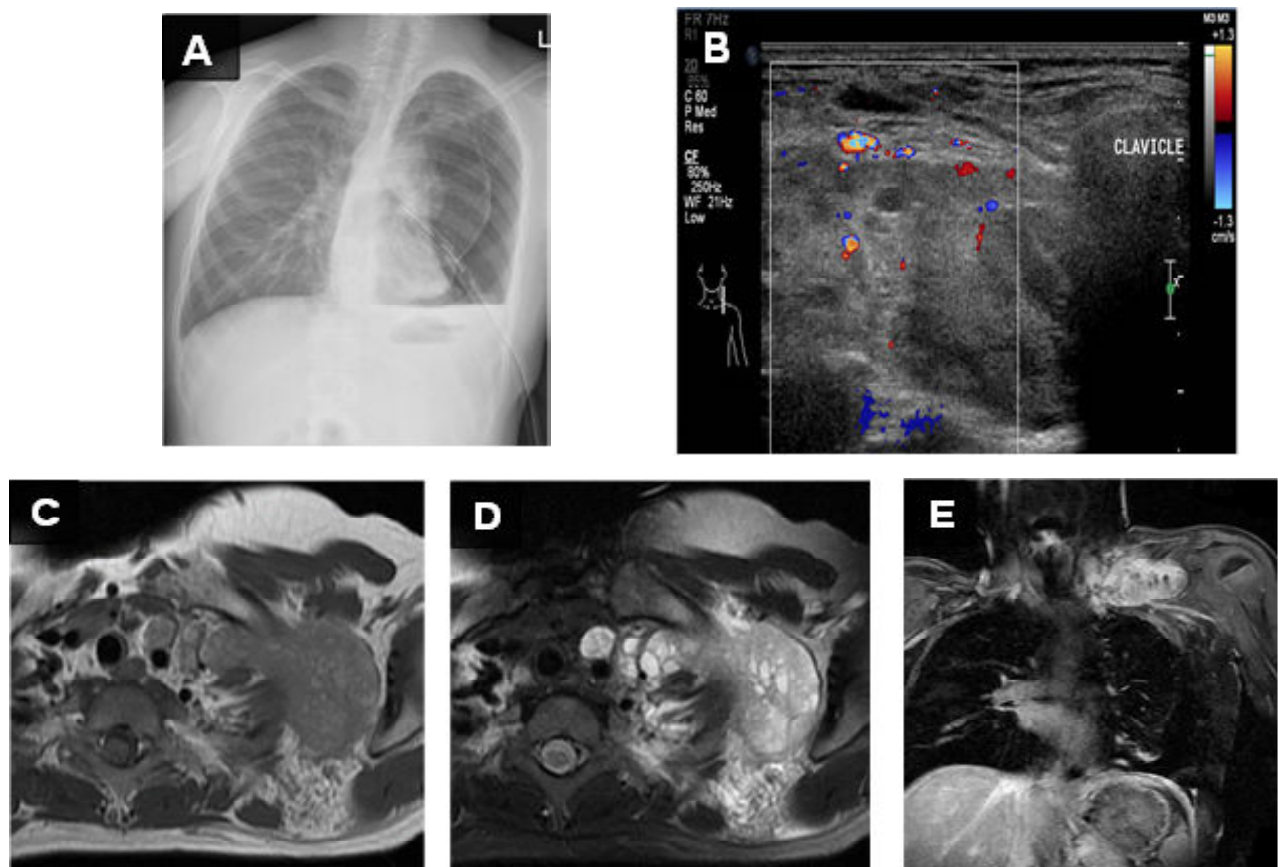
A 12-year-old boy had chronic cough, progressive dyspnea, and chest pain. (A) The initial radiograph revealed moderate left pneumothorax and minimal left pleural fluid after placement of the left intercostal drainage. (B) Subsequent ultrasound found heterogeneous echogenic solid and cystic mass, predominantly solid, in the anterior mediastinum and the left side of the neck. Chest MRI showed the lobulated infiltrative mass in the left apical hemithorax and left lower neck, which had a slight hypersignal intensity on the T1-weighted image (C), a bright signal intensity on the T2-weighted image (D), and intense enhancement after injection of a gadolinium-based contrast agent (E).
